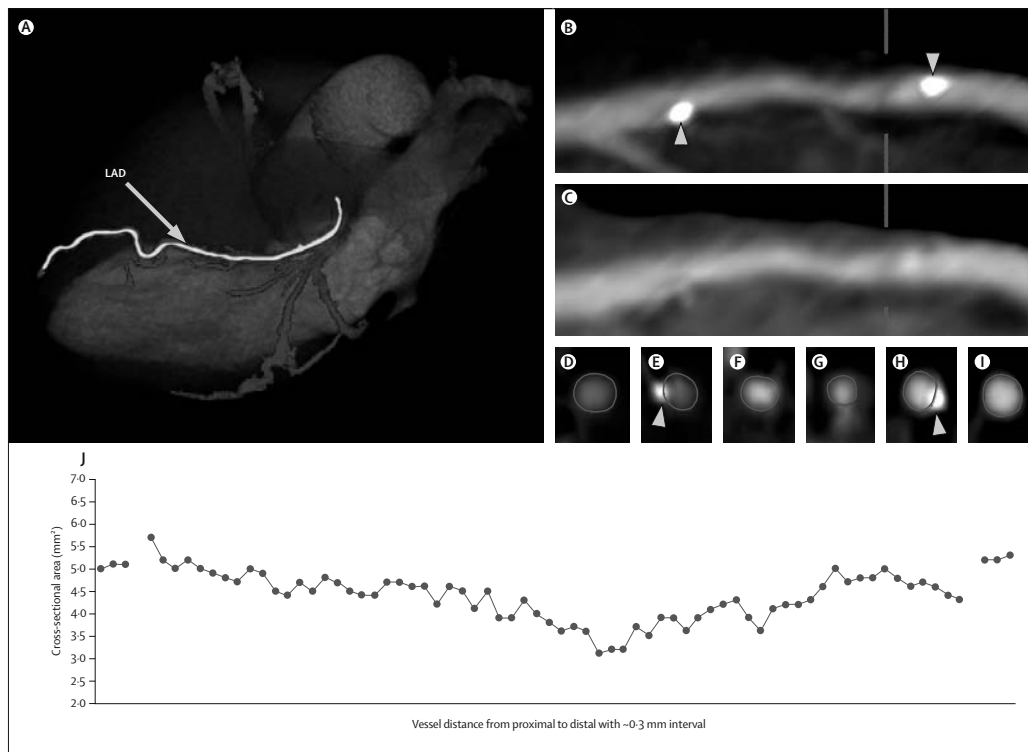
Results from multislice CT
